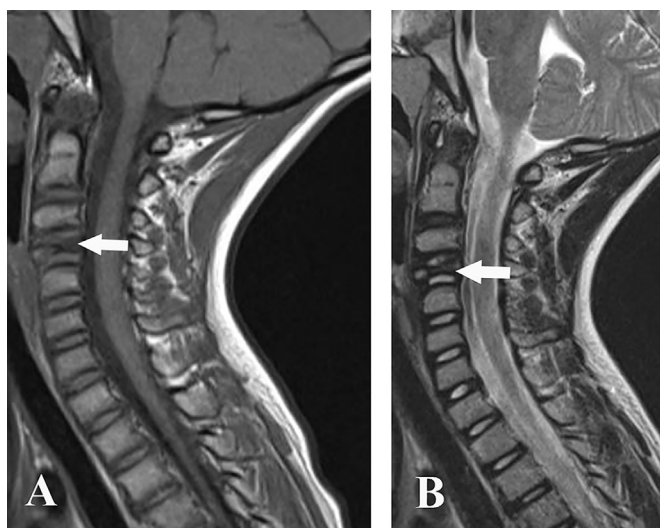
A. T1 weighted MRI of the cervical spine demonstrates flattening and sclerosis of the vertebral body without involvement of the disc (arrow). B. T2 weighted MRI of the cervical spine shows flattening and sclerosis of the vertebral body without involvement of the disc (arrow). There is no evidence of soft tissue mass and no involvement of the spinal canal.
